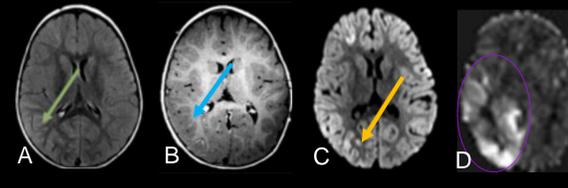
18-month-old male with altered mental status, fever, and lethargy diagnosed with meningoencephalitis of unknown etiology. Traditional images demonstrate subtle sulcal FLAIR hyperintensity (A), minimal leptomeningeal enhancement (B), and faint patchy restricted diffusion (C). PASL reveals marked hyperperfusion (D) related to active infection/inflammation.
